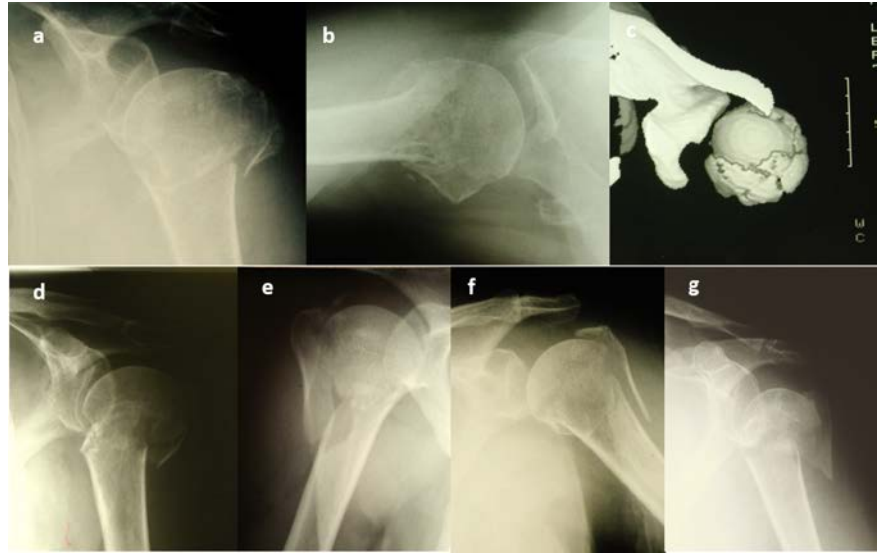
a-c) Typical example of 4-part VI fracture in two radiographic planes (a) anteroposterior and (b) axillary; c) computed tomography scan showing the spread of both tuberosities and the impaction of the humeral head. d-g) Other examples of 4-part valgus impacted fractures with different degrees of humeral head impaction and tuberosities displacement.
